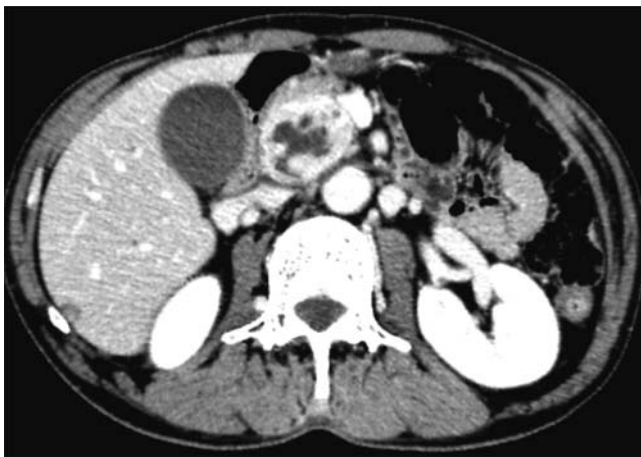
Computed tomography showed a well-demarcated mass in the head of the pancreas with a heterogeneous enhancing pattern.
